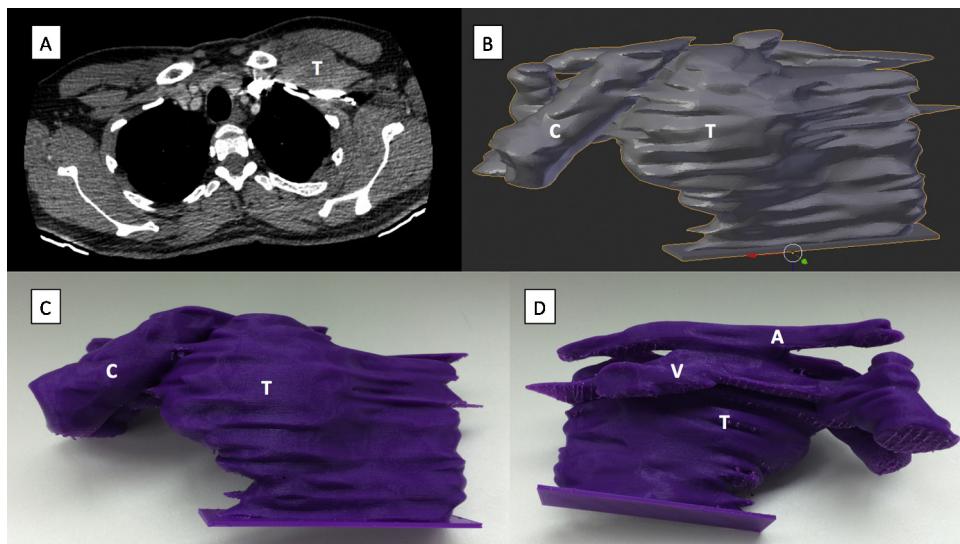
Chest wall spindle cell neoplasm. (A) Computed tomography of the tumor (T). (B) 3D rendering of extracted topology showing the tumor (T) with clavicle (C). (C) Anterior side of the 3D printed plastic model with tumor (T) and clavicle (C). (D) Posterior side of the 3D printed plastic model with subclavian artery (A), subclavian vein (V) and tumor (T).
